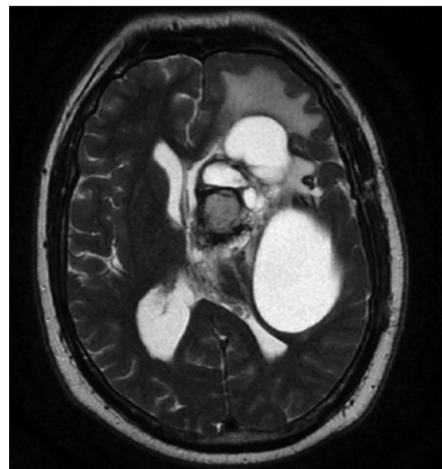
T2-weighted axial image: Large intra-axial lesion in the left hemisphere, with cystic components and heterogeneous signal intensity.
